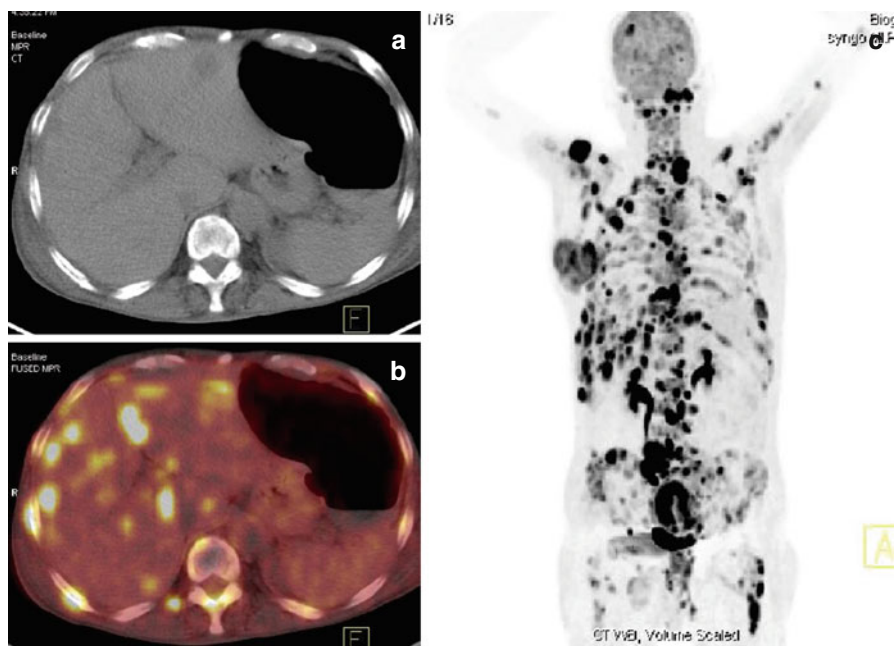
PET/CT in a 49-year-old man with rectal adenocarcinoma revealed multiple hypodense lesions in CT (a) with corresponding increase in FDG uptake in the fused PET-CT images (b) The maximum intensity projection (MIP) images (c) showed extensive nodal, skeletal and bilateral lung metastases
